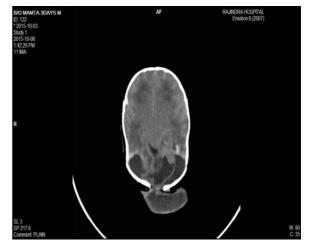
Alive baby CT scan demonstrates occipital meningocoele associated with Dandy-walker malformation and a posterior fossa cyst.
